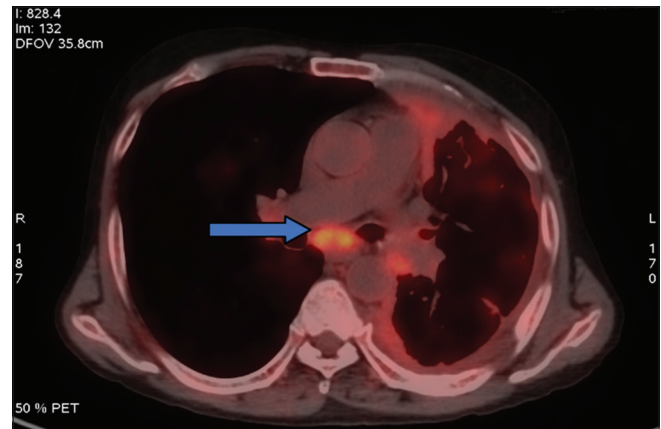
Positron emission tomography-computed tomography axial section showing subcarinal node
